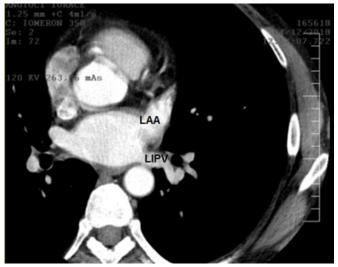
Computed tomography of the heart. Left atrial appendage and left inferior pulmonary vein. LIPV has a posterior orientation.
